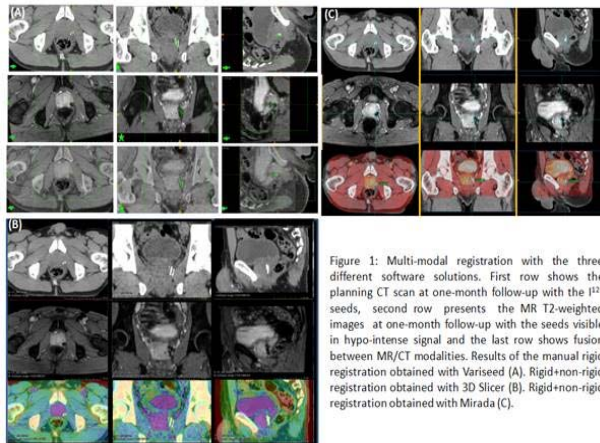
Multi-modal registration with the three different software solutions. First row shows the planning CT scan at one-month follow-up with the I125 seeds, second row presents the MR T2-weighted images at one-month follow-up with the seeds visible in hypointense signal and the last row shows fusion between MR/CT modalities. Results of the manual rigid registration obtained with Variseed (A). Rigid+non-rigid registration obtained with 3D Slicer (B). Rigid+non-rigid registration obtained with Mirada (C).
